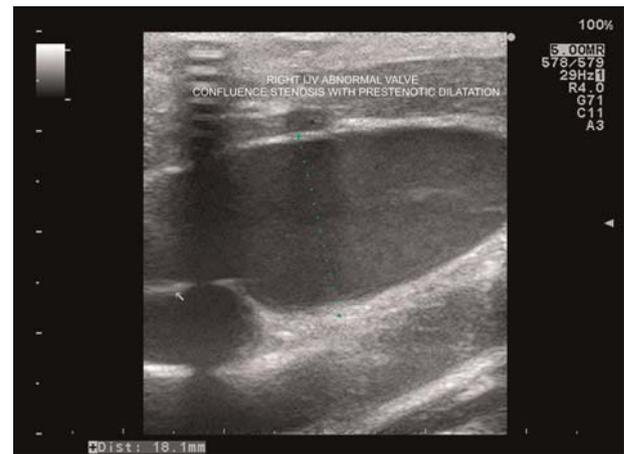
Colour Doppler sonography: right IJV confluence stenosis with prestenotic dilation – spontaneous diameter >15 mm with decreased blood flow velocity (BFV, < 20 cm/second) and increased in-site stenotic BFV >130 cm/second
